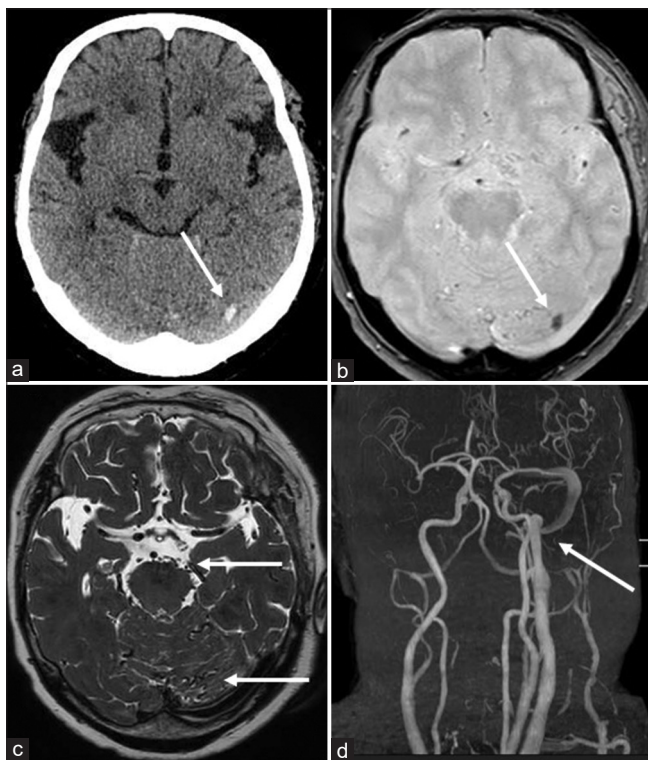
Imaging findings on admission (a and b) CT shows a slight high-density area in the left occipital lobe (arrow), which is hypointense on T2 star weighted image of MRI (arrow). (c) T2-weighted image of MRI shows flow voids around the cerebellum and brainstem (arrows). (d) MRA clearly visualizes the IJV and sigmoid sinus (arrow), and venous reflux into the anterior condylar vein and cavernous sinus can also be confirmed. CT: Computed tomography, MRI: Magnetic resonance imaging, MRA: Magnetic resonance angiography, IJV: Internal jugular vein.
